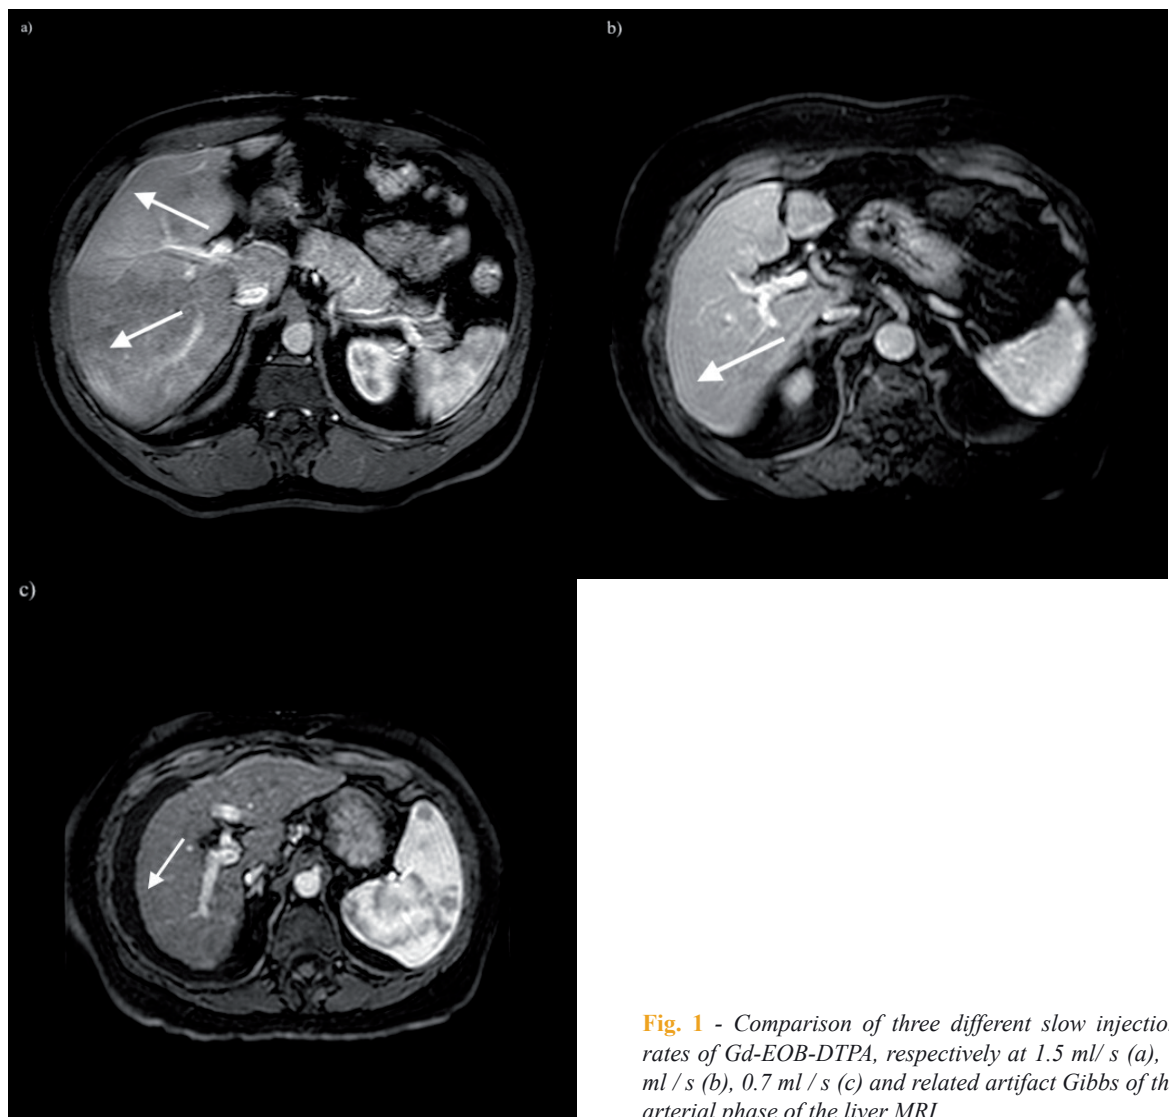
Comparison of three different slow injection rates of Gd-EOB-DTPA, respectively at 1.5 ml/s (a), 1 ml/s (b), 0.7 ml/s (c) and related artifact Gibbs of the arterial phase of the liver MRI.
